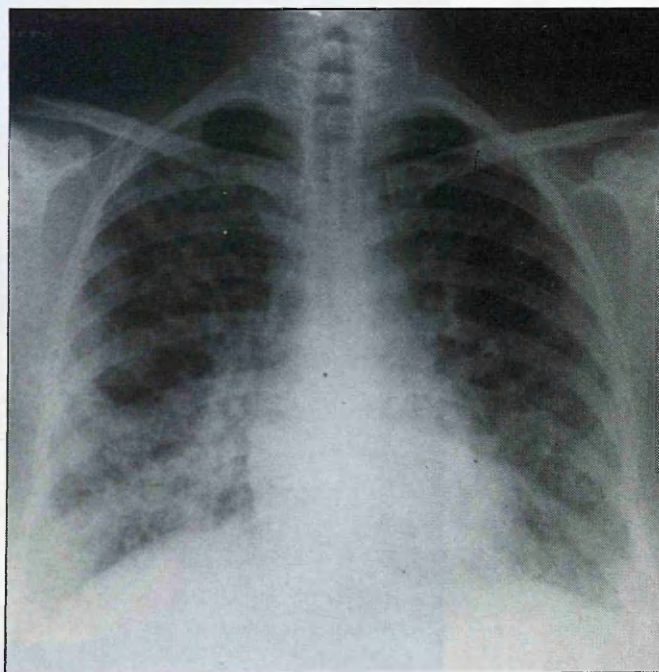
Chest X-ray of the same patient with diffuse active Tuberculosis.
